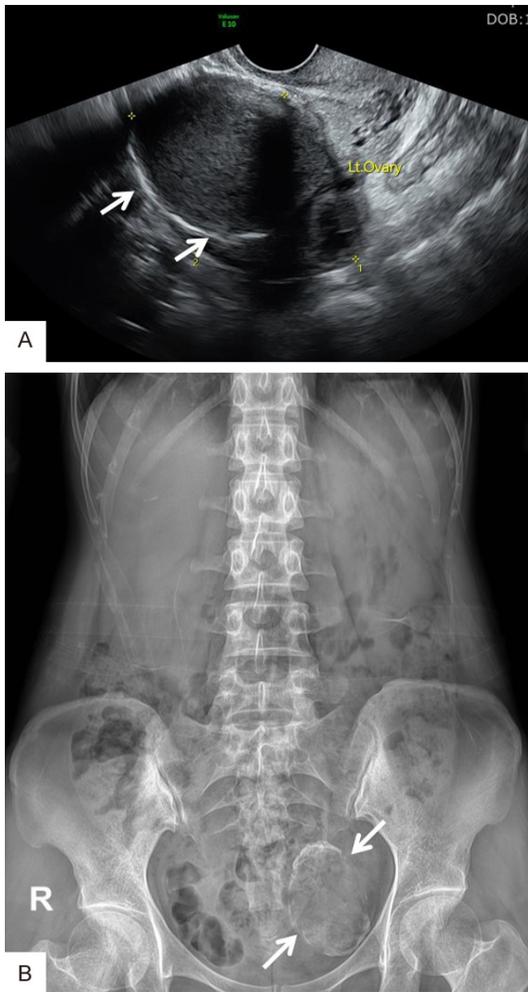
Ultrasonography and plain radiography findings. A. Transvaginal ultrasonography revealed a homogeneous echogenic lesion with a hyperechoic rim (arrows) of the left ovary. B. Plain radiograph of the abdomen showing an ossifying mass (arrow), measuring 7.7 cm × 5.1 cm, on the left side of the pelvis.
